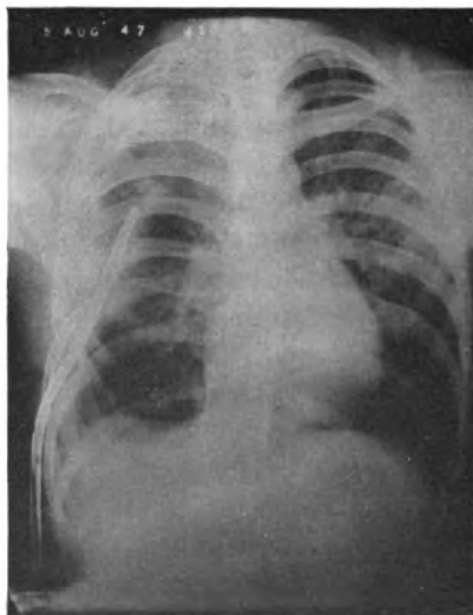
Case 6. Roentgenogram after application of suction for 6 weeks. The cavity has obliterated but there remains considerable residual pleuritis. The short tube is in the sinus in the thoracic wall.
